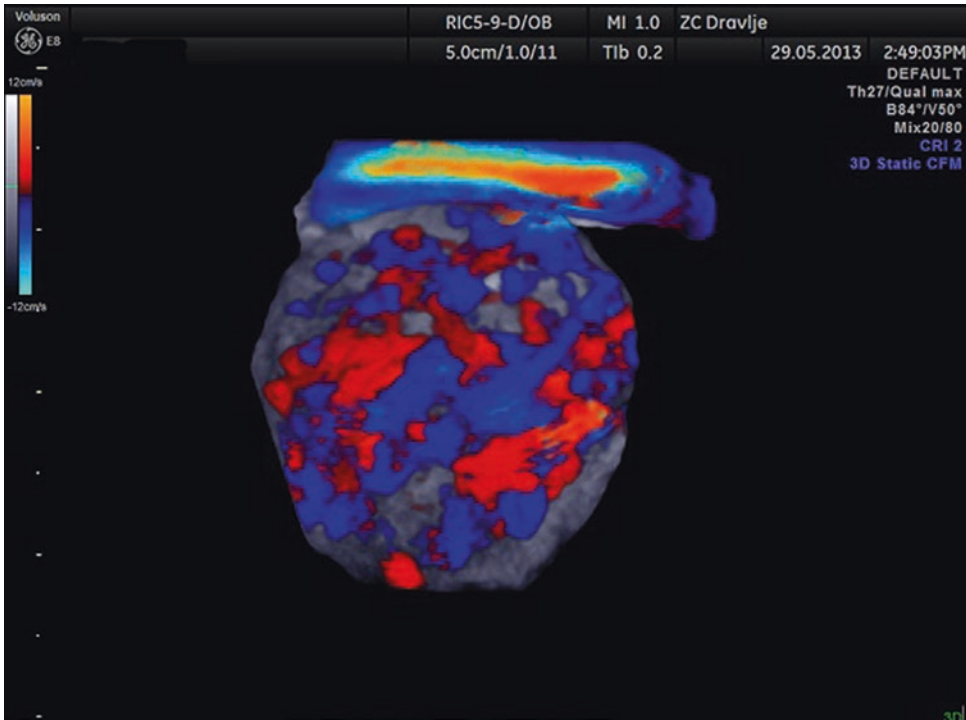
3D color Doppler vascularization of dominant follicle before ovulation
